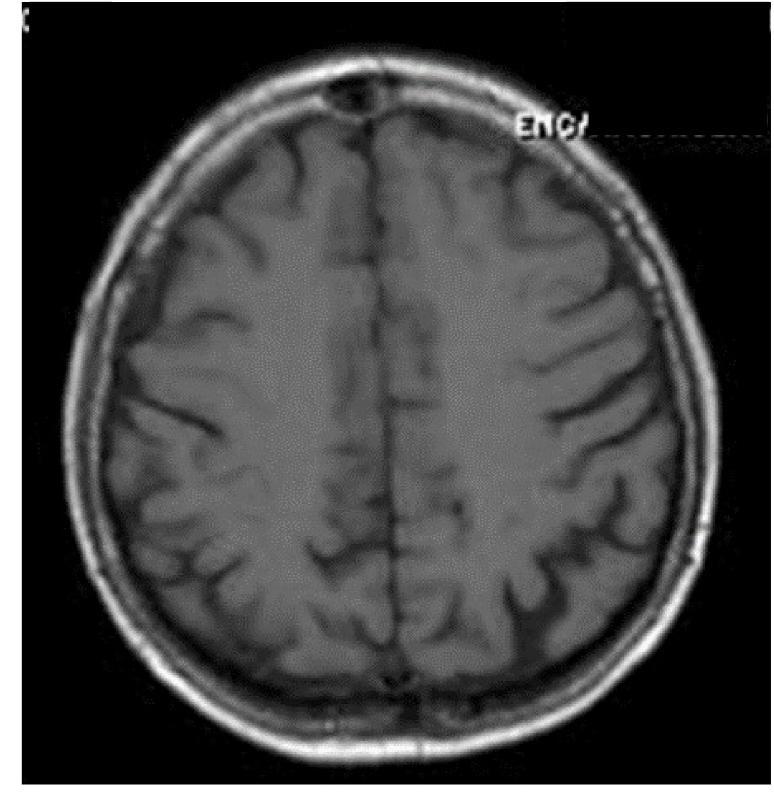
Brain MRI small subcortical T2-hyperintense gliotic lesions (a) with no cerebellar atrophy (b)
